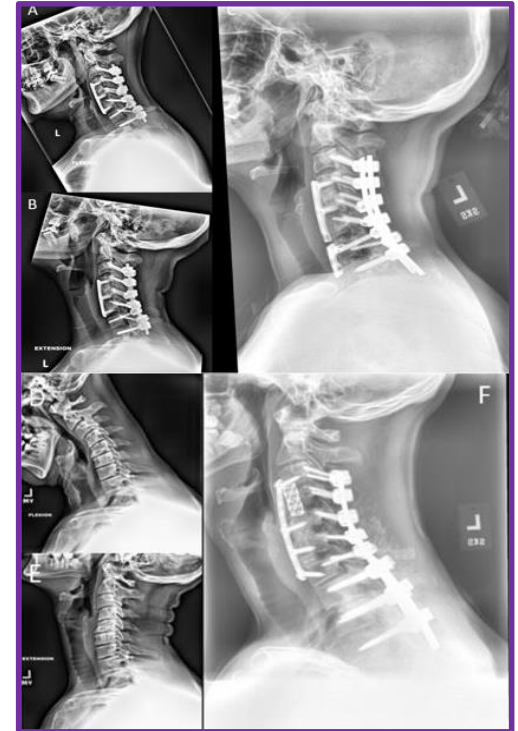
(A-C): Preoperative flexion/extension and postoperative x-rays in a patient with a rigid cervical deformity requiring a PSO at T1. (D-F): Preoperative flexion/extension and postoperative x-rays in a patient with a flexible cervical deformity requiring anterior/posterior fusion C3-T3.
